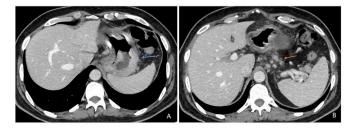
Axial abdominal CT scan: Tissue thickening of the large gastric curvature (blue arrow) (A) associated with perigastric and splenic hilum adenomegaly (orange arrow) (B)
